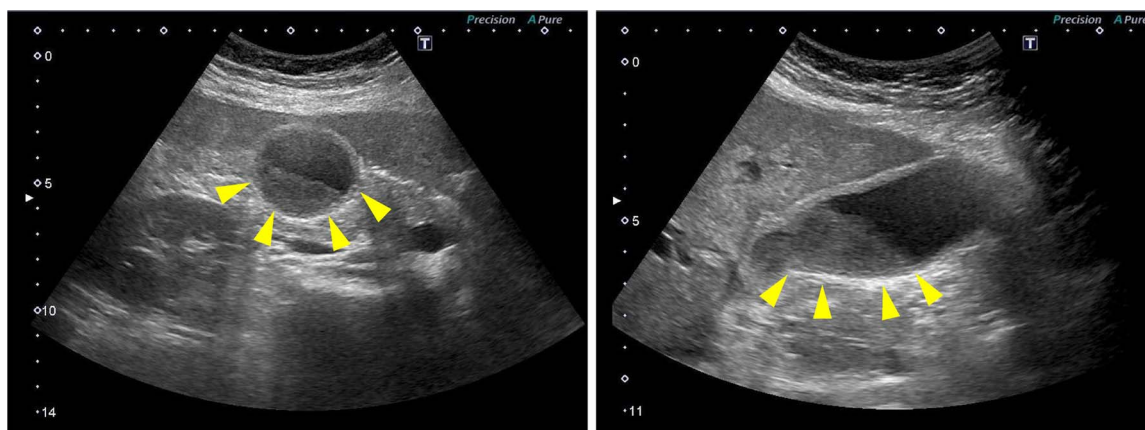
Abdominal ultrasound on admission revealed a distended gallbladder, thickening of the gallbladder wall, and biliary sludge (arrowheads).
